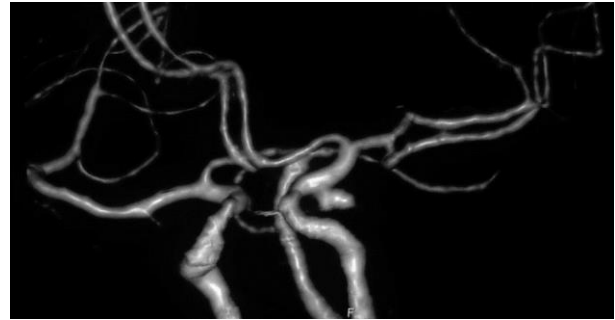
Left anterolateral CT angiogram showing left pure posteriorly directed PCoA aneurysm.
